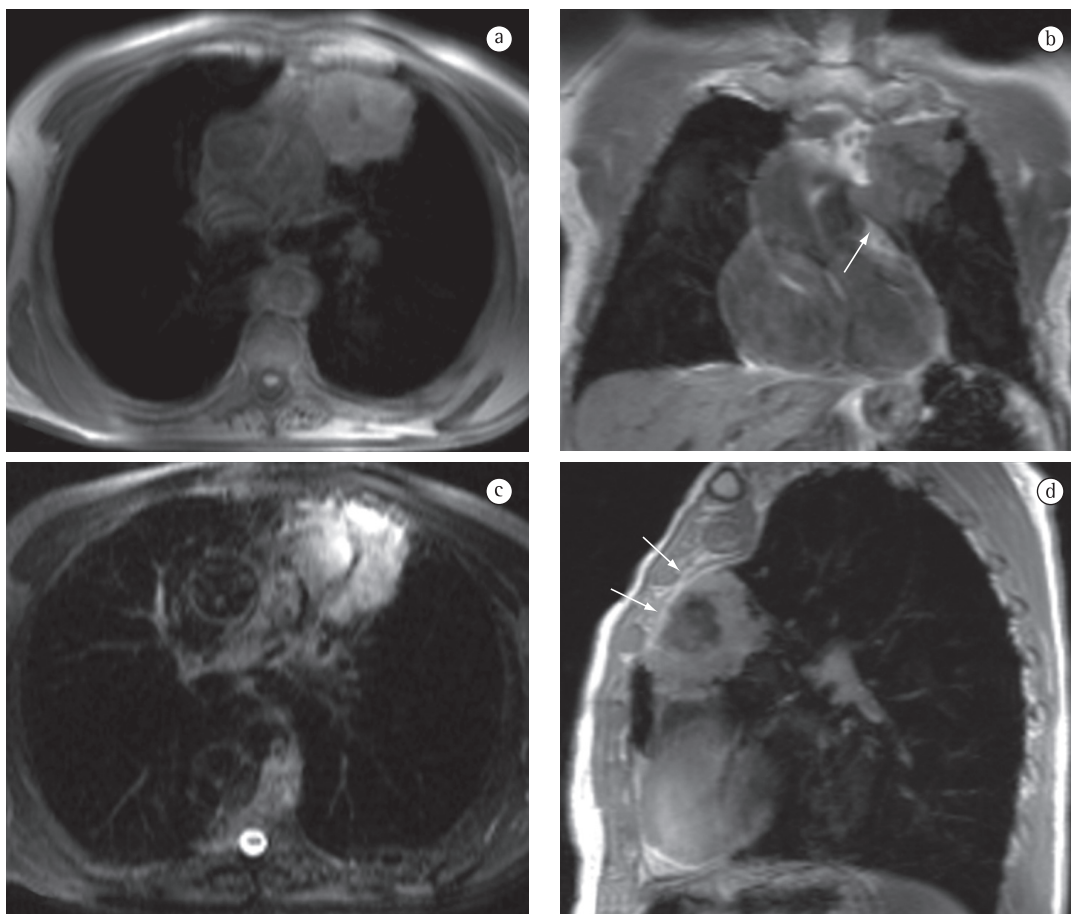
Magnetic resonance images showing pulmonary epidermoid carcinoma of the lung as a paramediastinal lesion. Axial T1-weighted image (a), coronal T1-weighted image (b), axial T2-weighted image (c), and sagittal T1-weighted image after the administration of a paramagnetic contrast agent (d). The mass is irregular and heterogeneous, hypointensity on T1-weighted images and hyperintensity on T2-weighted images predominating. The mass also presents heterogeneous contrast enhancement, with a hypointense central area of necrosis. Note mediastinal fat invasion at the aortopulmonary window (arrow in B) and a wide surface of contact with the anterior chest wall, although without direct signs of invasion (arrows in d).
